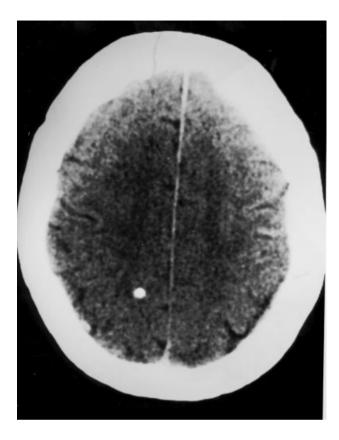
Computed tomography, showing a parenchymal brain calcification, the most conspicuous sequel of neurocysticercosis and a frequent cause of epilepsy in endemic areas
